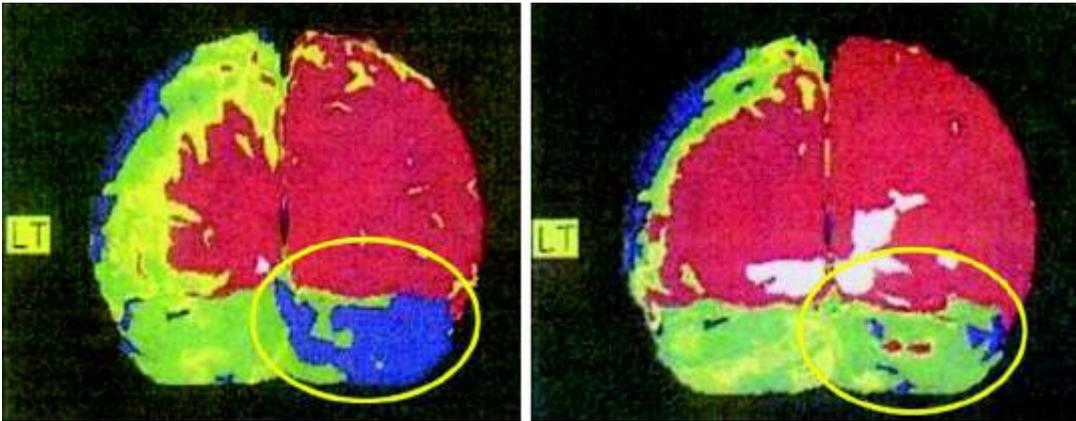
PET CT Scan showing improved metabolic activity which is indicated by decrease in blue areas after stem cell therapy
